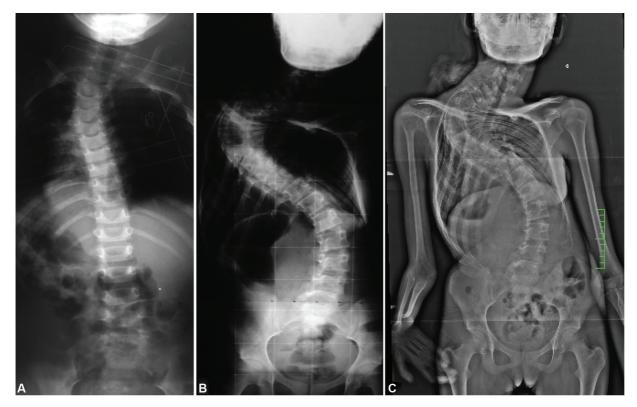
Radiographic progression of adolescent idiopathic scoliosis from 2005 (A), in 2010 (B), and in 2013 (C).
